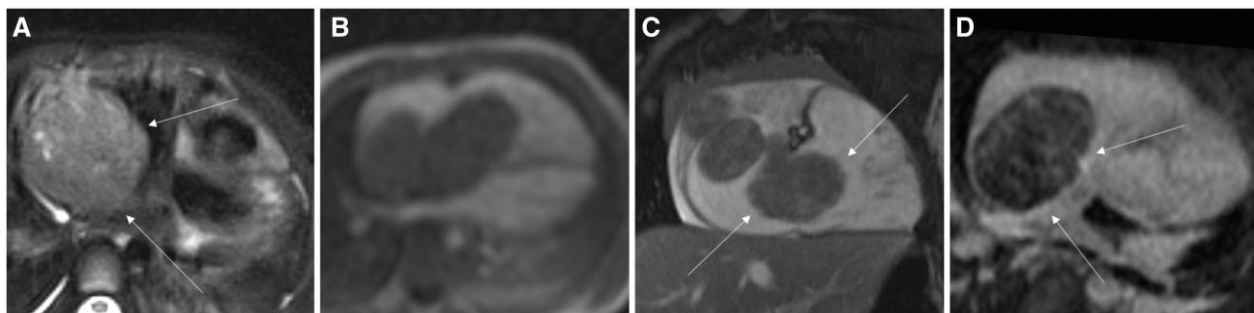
Cardiac magnetic resonance imaging. Pre-operative cardiac magnetic resonance imaging demonstrating a large lobulated right atrial mass that shows heterogeneous mildly hyperintense signal on T2-weighted sequences (A), no early enhancement on first pass perfusion (B), along with mild heterogeneous enhancement on both post-contrast SSFP cines (C) and 3D delayed gadolinium enhancement sequences (D).
